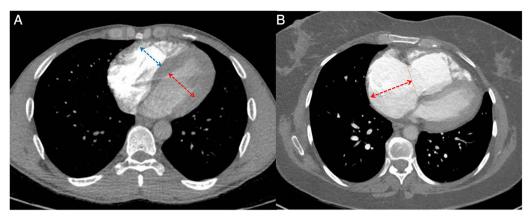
(A) The maximum mid-transverse diameters of the RV (right arrow) and LV (left arrow) cavities were measured in the axial plane at their widest points between the inner surfaces of the free wall and the interventricular septum. (B) For assessing the right atrial margin (arrow) on CT, right atrial length was measured from the centre of tricuspid annulus to the superior right atrial margin. RV, right ventricle; LV, left ventricle.
